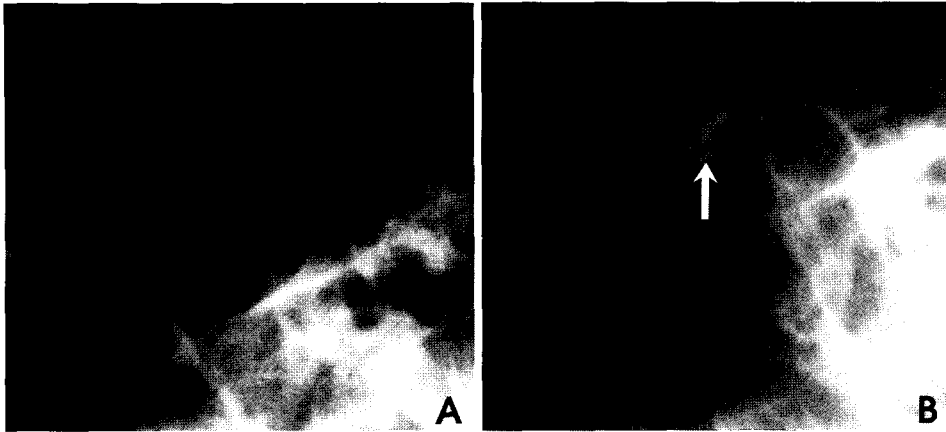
Transcranial radiographs show erosion and sclerosis of the articular eminence at unaffected side in same patient as Fig. 6. A, immediately after operation B, 9 months after operation
